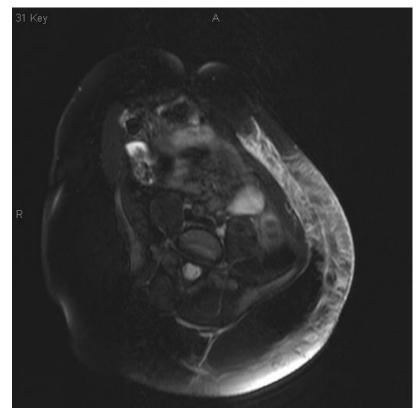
Necrotizing fasciitis appears on a T2-weighted MRI scan of the mid-abdomen.
